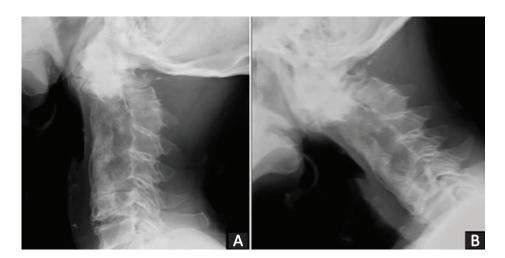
Extension (A) and flexion (B) lateral view radiographs showed fusion of C1-C6 with no signs of instability.
